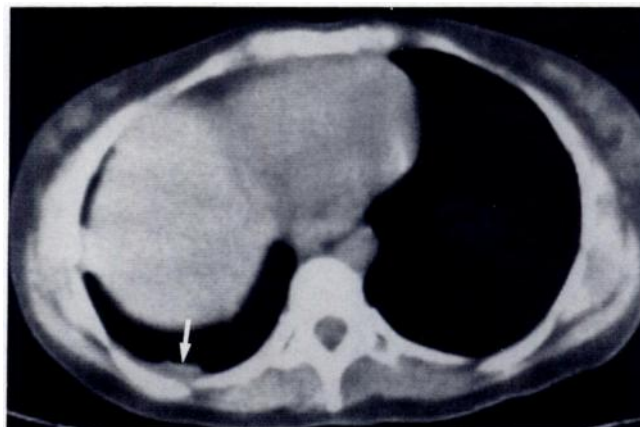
CT image shows pleural metastases (arrow) from adenoid cystic carcinoma. The lesions were proved by biopsy.
